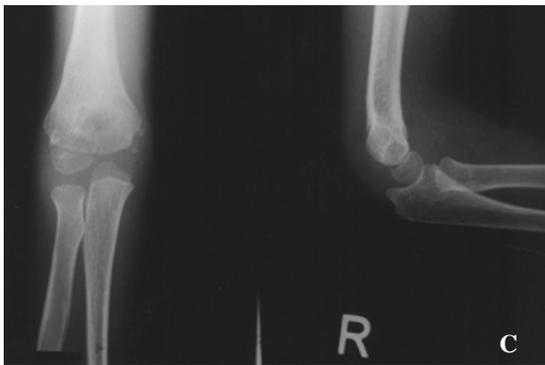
A. Preoperative radiographs show complete, posteromedial displacement of distal fragment of supracondylar fracture.
